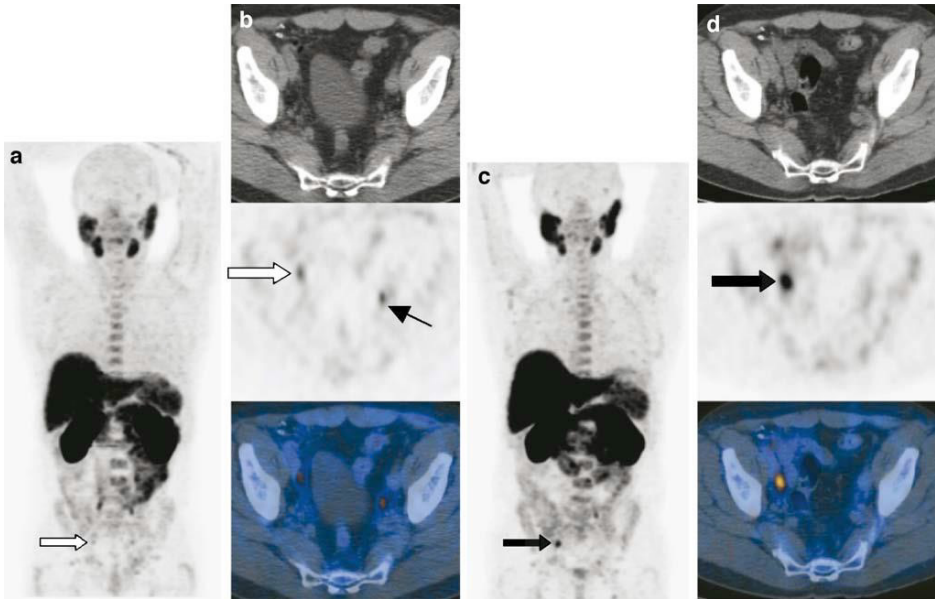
Pelvic lymph nodes involved in 18 – F fluorocholine PET and PET-CT
